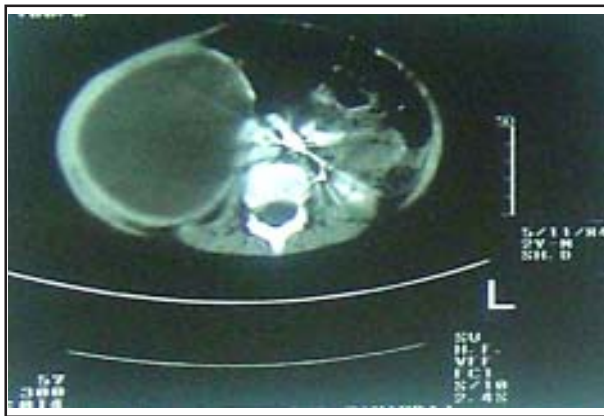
Abdominal CT scan with contrast of patient showed a cystic mass in the right hepatic lobe that induce right kidney shift.
